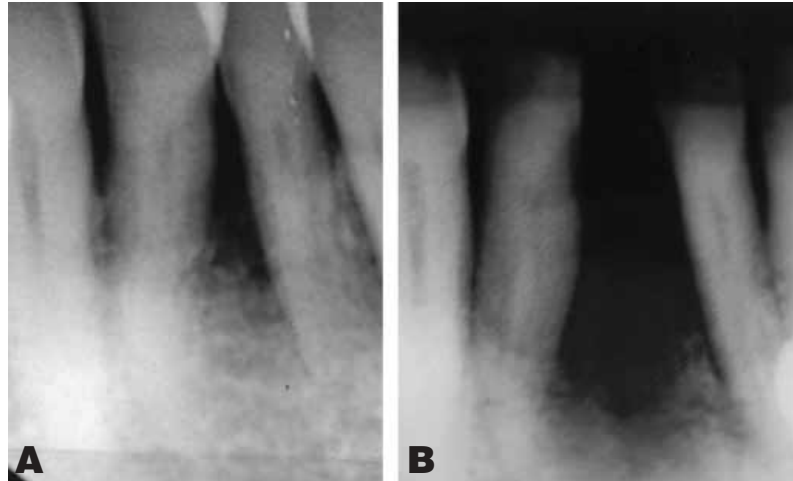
A, Preoperative radiograph showing interproximal radiolucency. B, Periapical film showing a crater-shaped radiolucency with irregular borders 3 weeks after extraction of tooth #24.
